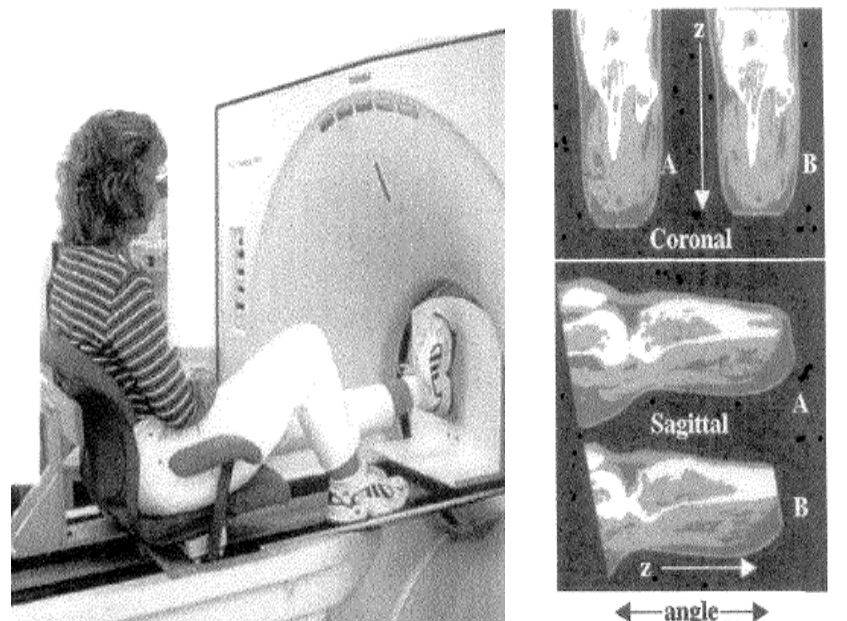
Spiral CT examination used for pistoning measurement (Madsen *et al.*, 2000).
